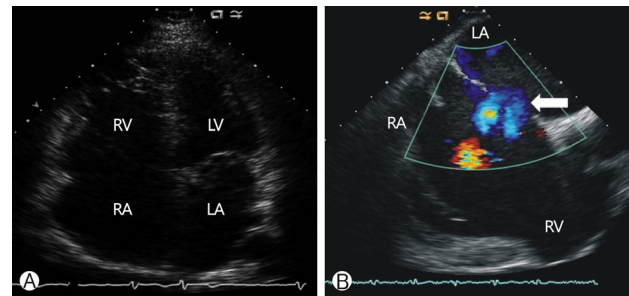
Preoperative echocardiography. A 65-year-old male had a known ASD (secundum type; 2 defects; Qp/Qs=2.0; pulmonary arterial pressure=53/24 mmHg) and a persistent presence of dyspnea on exertion (New York Heart Association class II of IV). (A) The enlargement of RV and both atria, (B) Two defects of secundum type ASD on the color doppler (arrow). ASD, atrial septal defect; RV, right ventricle; LV, left ventricle; RA, right atrium; LA, left atrium.
